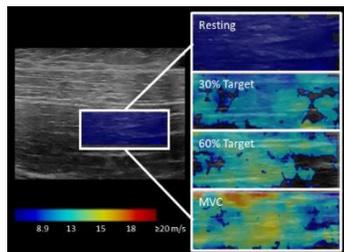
An ultrasound image in the longitudinal plane of the brachialis and overlaid shear wave velocity color maps from a variety of contraction intensities for a representative subject. Increasing warmth (fewer blue pixels) indicates greater shear wave velocity.
